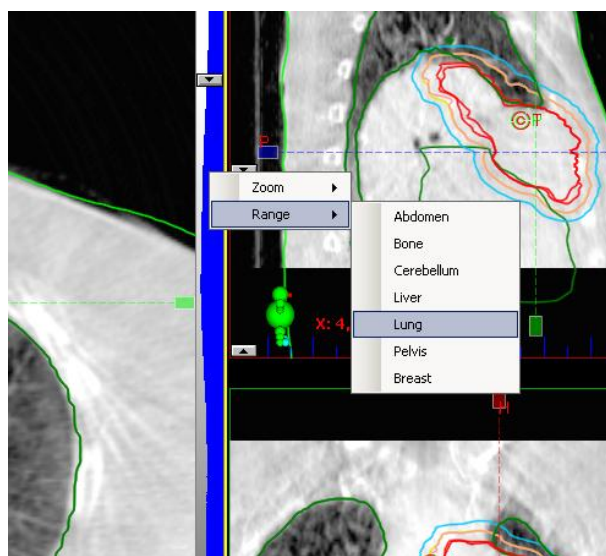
Choice of “window-level” for best visualization of lung tumor in CBCT.
